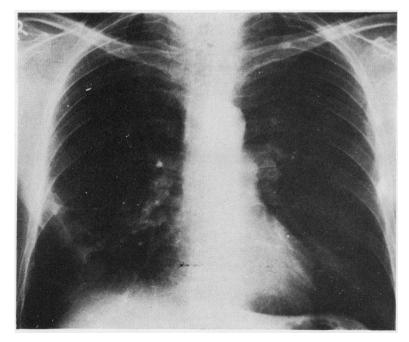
Chest radiograph four months later. Normal right and left lung fields with residual pleural thickening and adhesion on the right.
